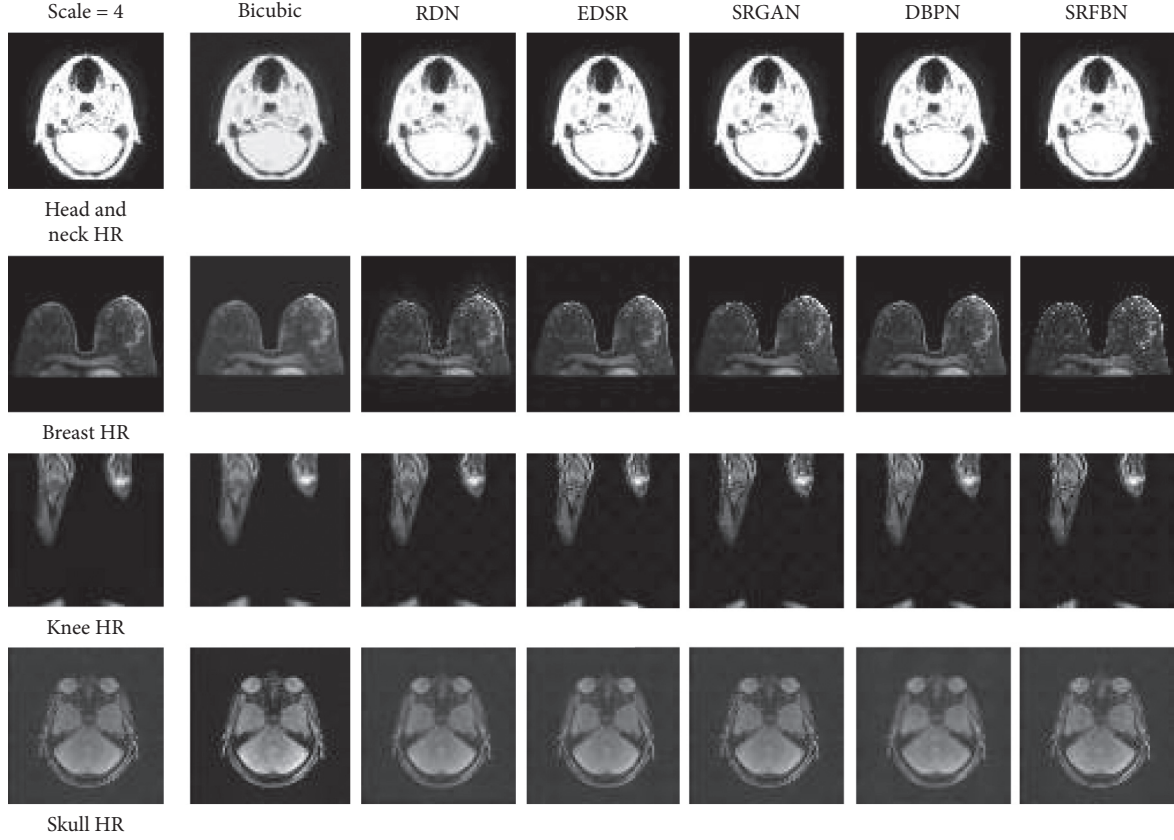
HR comparison of different super-resolution deep networks for each MRI data with scale = 4.
